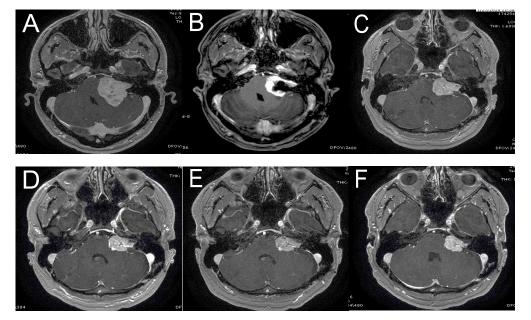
Imaging of Tumor. MRI showing cerebellopontine angle mass extending into the left external auditory canal before surgery (A), immediately post-craniotomy (B), baseline before bevacizumab (C), 8 months post-bevacizumab (D), with slight shrinkage of tumor, pre-OKN-007 and NAC (E), and 4 months post-OKN-007 and NAC (F) with stable disease.
